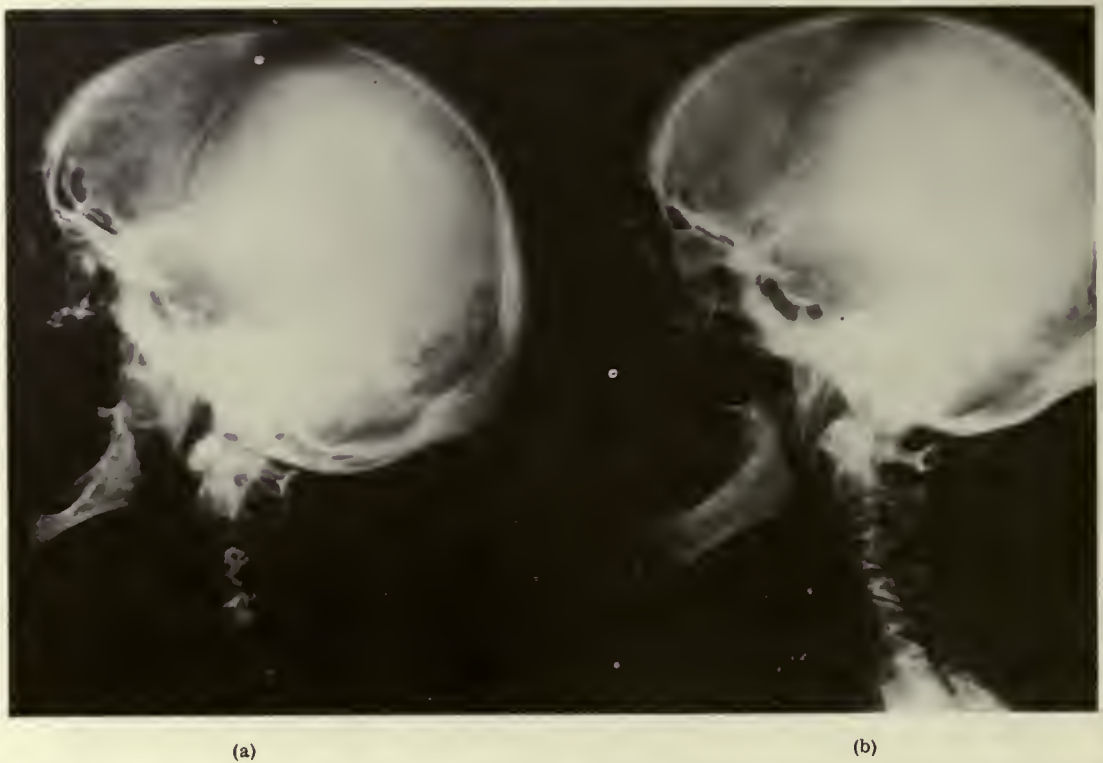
Conventional radiograph of chordoma in nasopharynx. (a) Before 2-Mv therapy. (b) After therapy.
